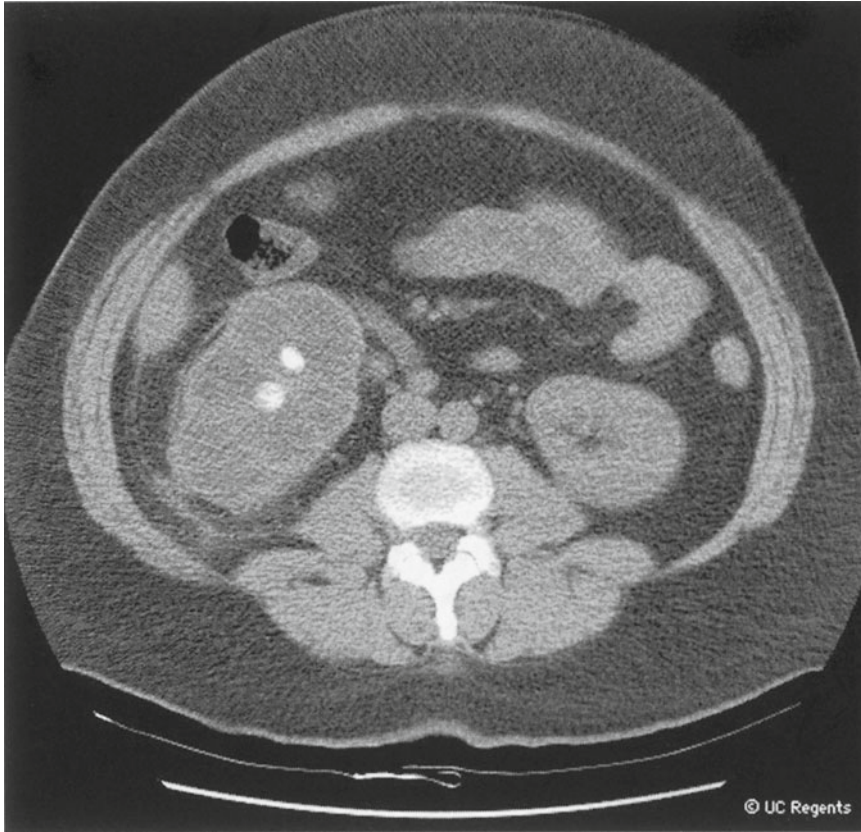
Non-contrast CT in a patient with right xanthogranulomatous pyelonephritis. Note the calcifications, enlarged renal form, and areas of reduced attenuation, potentially representing pus, dilated calyces, or inflammatory tissue
